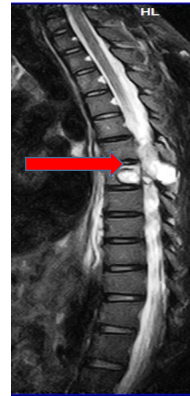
Spinal MRI showing high intensity on T2 at the level of T2 thoracic vertebra with bone marrow involvement.
